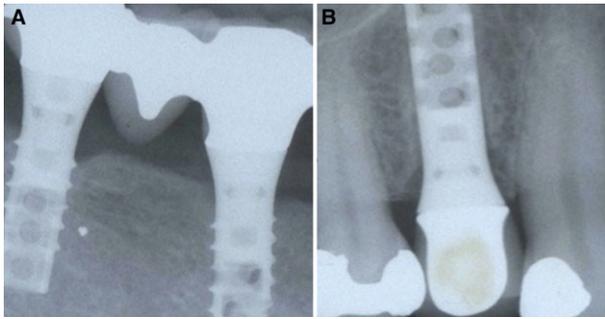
Radiograph showing hollow-screw implants (A) and a hollow-cylinder implant (B).
